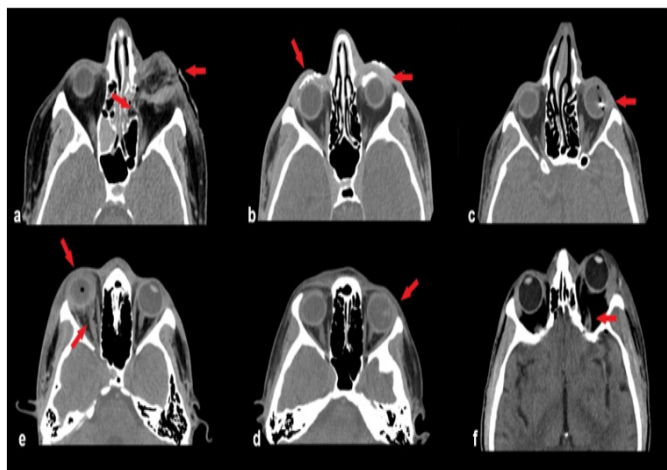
In the axial computed tomography examinations, a disorganized globe, left extraconal and intraconal heterogeneous density and millimetric air values were observed. Left medial rectus muscle is not observed (a), foreign body intensities are observed in bilateral preseptal areas (b), the millimetric metallic foreign body is observed in the left globe (c), deformation, haemorrhagic intensities, and millimetric air density are observed in the right globe. Loss of integrity and millimetric air densities are observed in the right optic nerve (e), the lens is not observed on the left, but it is observed in the vitreous fluid (d), and loss of integrity is observed in the left optic nerve (f) (red arrows to all)
